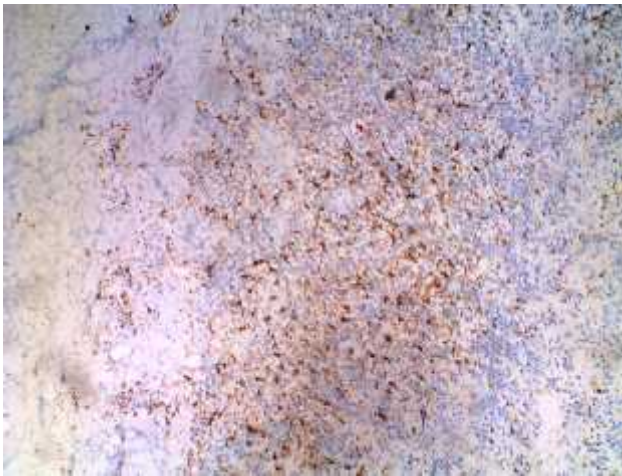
Differences in positive cell distribution within three layers of periapical cyst capsule with maximum expression in intermediate layer*
